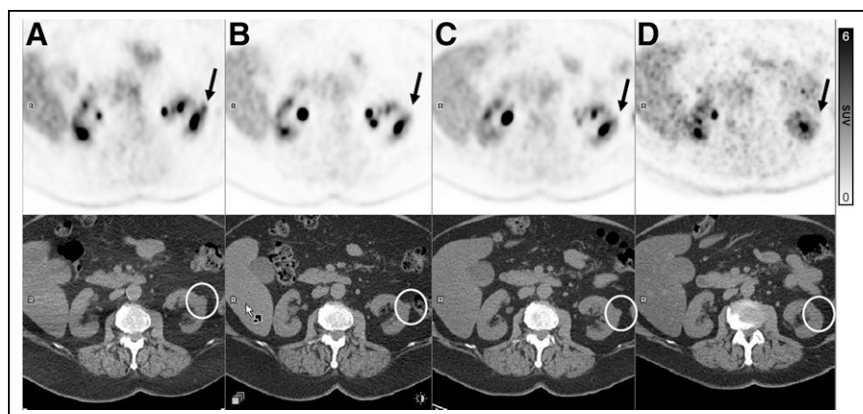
^{18}F -FDG PET axial (top row) and CT axial (bottom row) images from scan 4 (A), scan 3 (B), scan 2 (C), and scan 1 (D). CT axial images from limited WB ^{18}F -FDG PET/CT scan show incidental ^{18}F -FDG-avid exophytic 1.7-cm isodense nodule in mid left renal pole (circles). This lesion is new since scan 1, has slowly enlarged since most recent examination, and displays increased ^{18}F -FDG activity on scan 4 (arrows).
